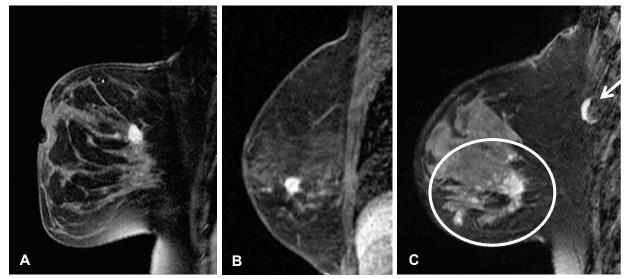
Examples of inconclusive breast imaging with positive MRI findings. (A) Distortion one-view only on mammography, normal ultrasound; MRI shows invasive lobular carcinoma. (B) Asymmetry on mammography with a normal US; MRI shows invasive ductal carcinoma. (C) Diffuse calcifications on mammography; MRI reveals DCIS (circle). Note enhancing incidental normal lymph node (arrow).
